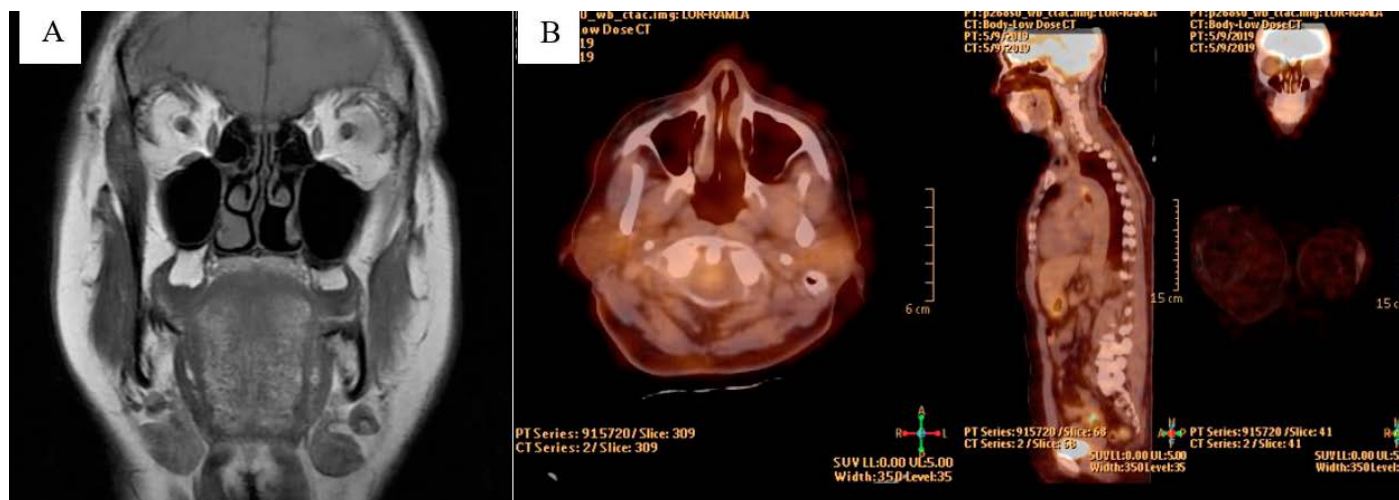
Magnetic resonance imaging (MRI) of the head and neck (A) and whole-body PET/CT (B) scan were clear of disease. Gross reduction of the posterior part of the left inferior turbinate can be observed.
